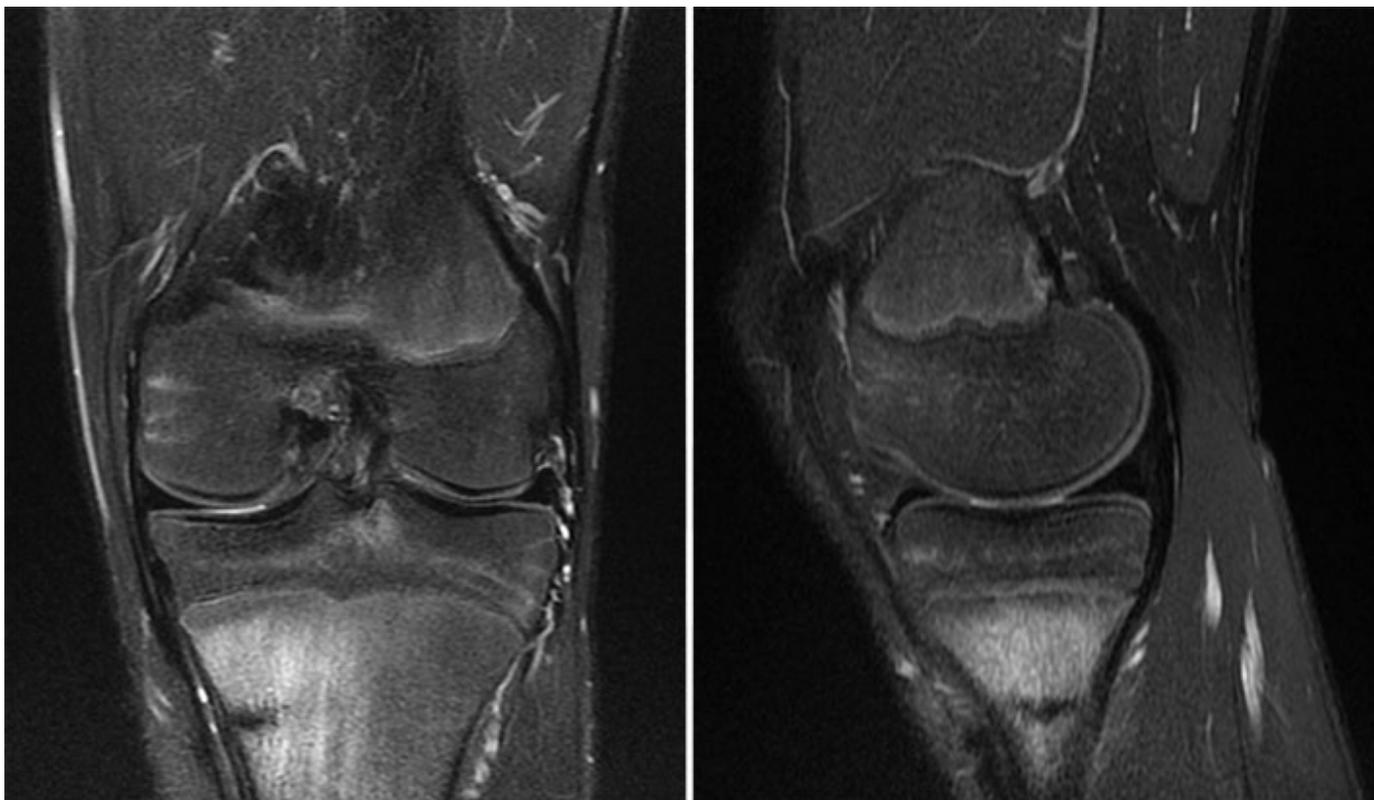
A 14-year-old male cross-country runner was experiencing knee pain. A knee MRI using T2 sequences revealed a stress fracture in the proximal tibia. Images courtesy of Randheer Shailam, MD, Pediatric Imaging, Department of Radiology, Massachusetts General Hospital.
